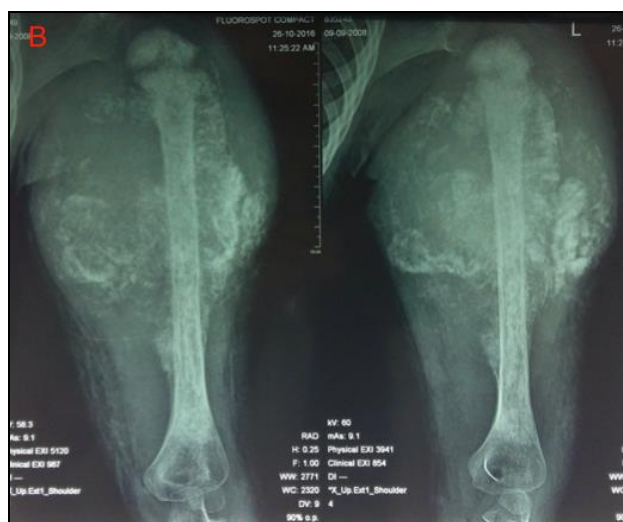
Radiography of Left Shoulder (A) Antero-posterior View; (B) Lateral View.
